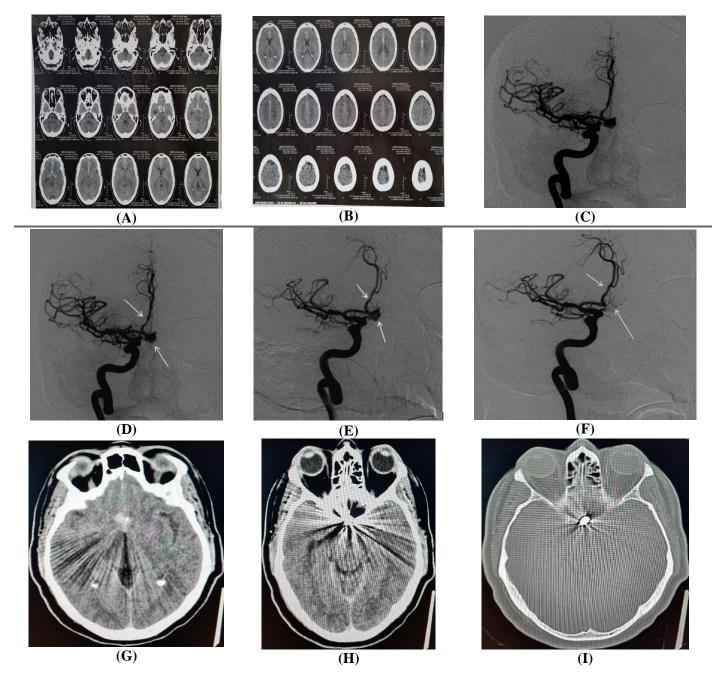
(A): CT brain scan was done showing subarachnoid hemorrhage (modified fisher grade 1), (B): CT brain scan was done showing subarachnoid hemorrhage (modified fisher grade 1), (C): Rt. ICA angiogram, AP view, showed anterior communicating artery aneurysm, (D): Before injection of intraarterial nimodipine, (E): After injection of intraarterial nimodipine, (F): Rt ICA angiogram AP view showed successful coiling of the aneurysm, (G), (H), (I): CT brain post-operative showing coils in the aneurysm.
